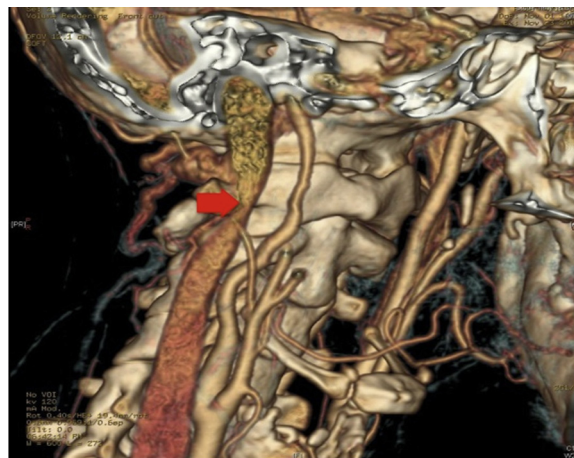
Angio-CT showing stenosis in cervical segment of the right internal carotid artery compatible with an internal carotid artery dissection.
